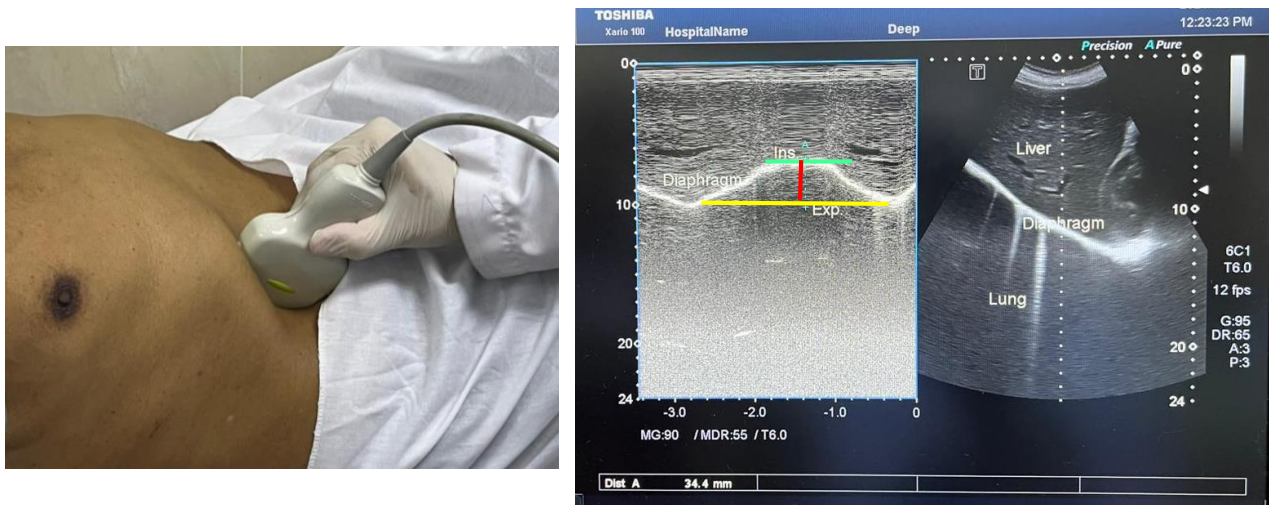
Ultrasound measurement of diaphragm excursion by motion mode in patient with COPD
